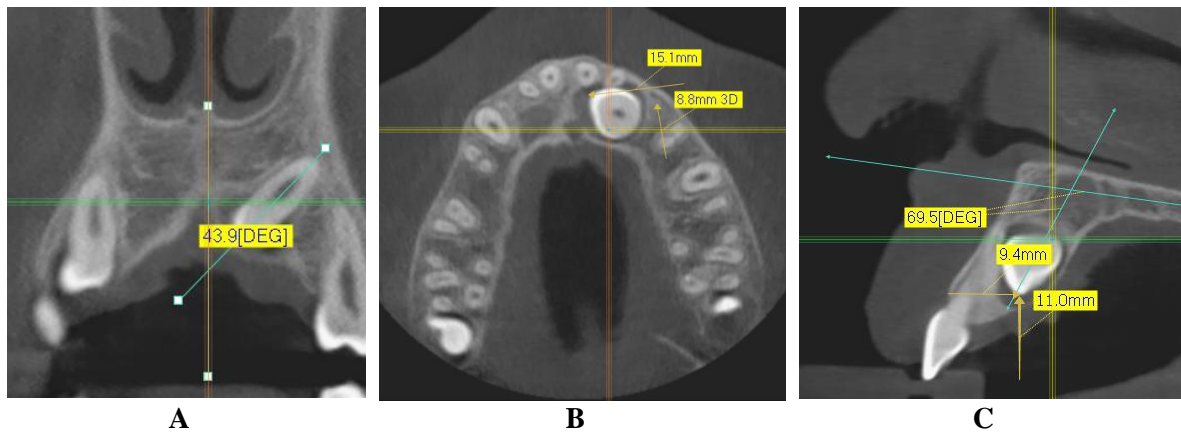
Different views of CBCT scan. A. coronal view (PIC to midline angle); B, axial view (cusp and apex deviation, cusp and apex distance to midline); C, lateral view (PIC to PP angle, vertical height and anterior position of cusp).
